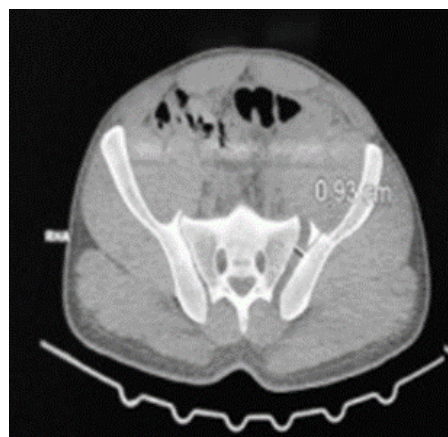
CT appearance of posterior lesions.
